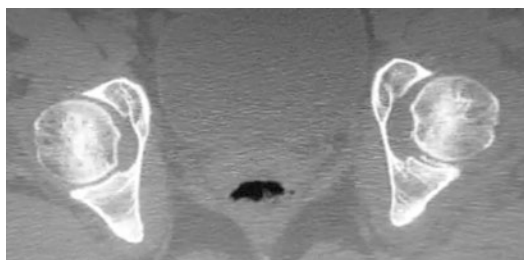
CT scanning revealed a loose fragment in the joint
